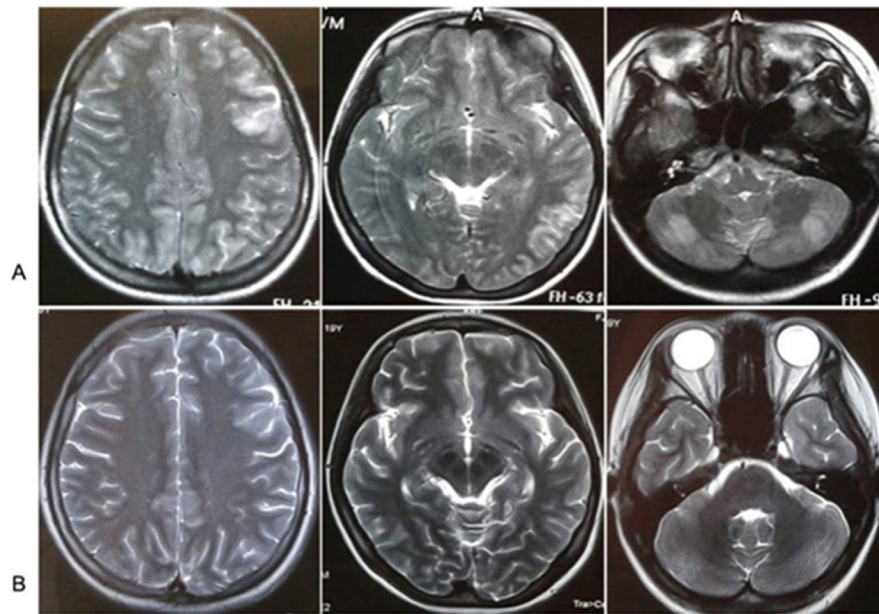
Brain magnetic resonance images (MRI) showed that multiple abnormalities varied from bilateral frontal, parietal, occipital-temporal lobe to cerebellum hemisphere on axial T2-weighted images (T2WI). Multiple abnormalities disappeared after steroids therapy. (A) MRI of the brain obtained before steroids therapy; (B) MRI of the brain obtained after steroids therapy
